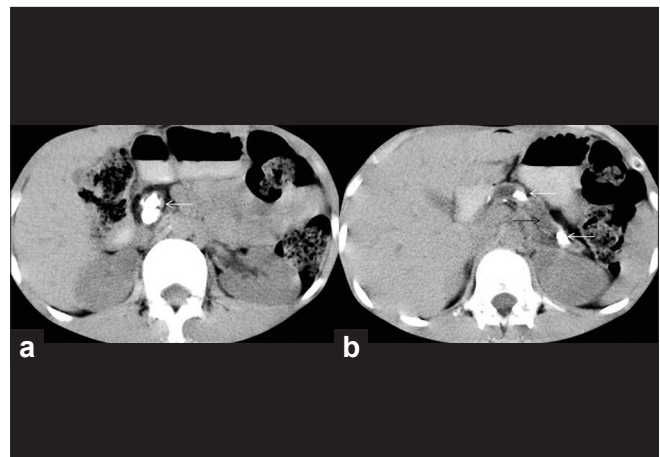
Chronic pancreatitis. Axial non-contrast CT abdomen shows features of chronic pancreatitis evidenced as atrophic pancreas, dilated main pancreatic duct (thin black arrow) and dense calcifications (thin white arrow) in pancreatic head region and within the dilated main pancreatic duct
